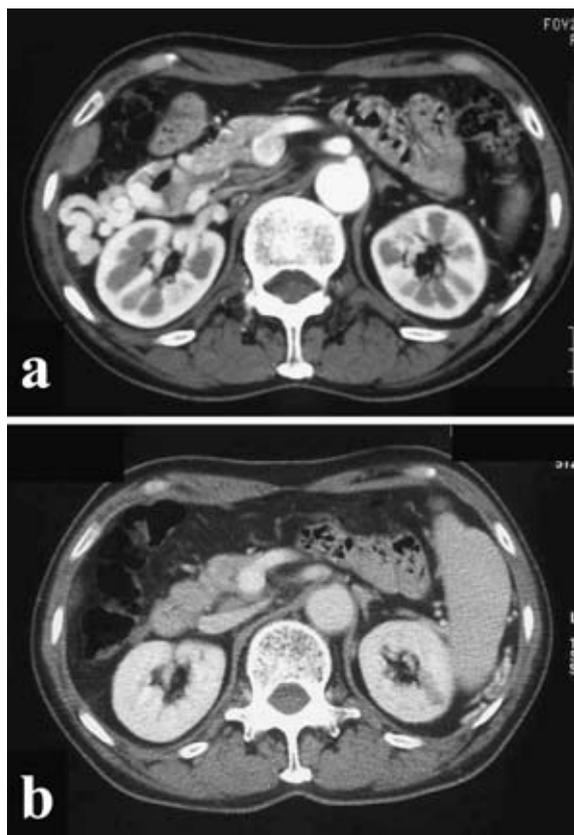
A computed tomographic scan obtained before treatment, showing varices around the second portion of the duodenum, with part of the varices protruding into the lumen of the duodenum (a). Three months after BRTO, the dilated varices had disappeared (b).
